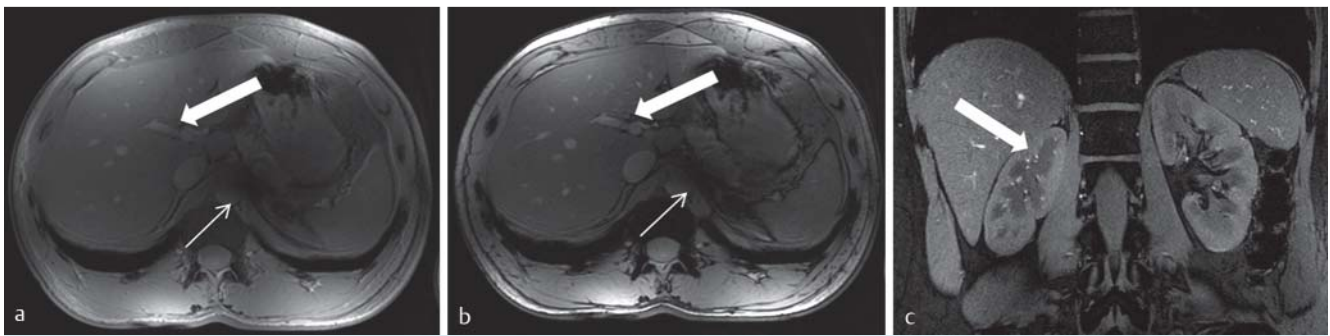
Non-enhanced T1-weighted 2D FLASH MRI of the abdomen at 1.5 T a, 3 T b and 7 T c demonstrating high-quality abdominal MRI at all three field strengths and the improved delineation of vessel structures at 7 Tesla due to an inherently hyperintense vessel signal c.
